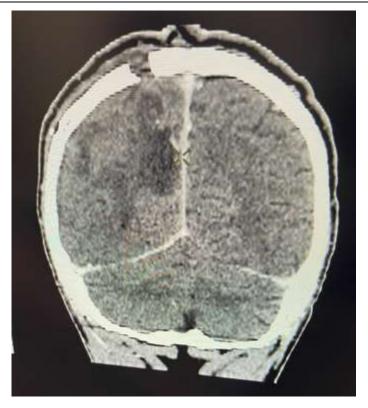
Cerebral CT Scan, Postoperatively, Coronal View
